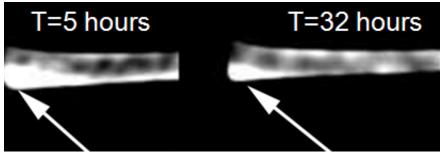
CT image of GNPs-based hydrogel sample after 5 hours (leftward) and 32 hours (rightward) immersion in water. The white arrows point to hydrogel sample, the attenuation of which remained stable throughout this time.
